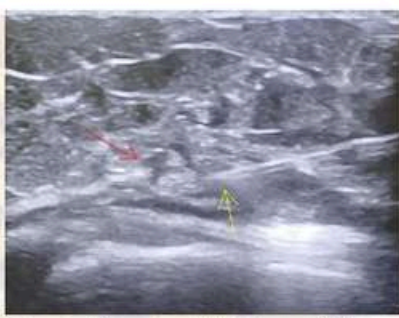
Ultrasound guided local anaesthetic diagnostic test with a needle (yellow arrow) over the infrapatellar branch of the saphenous nerve (red arrow).
